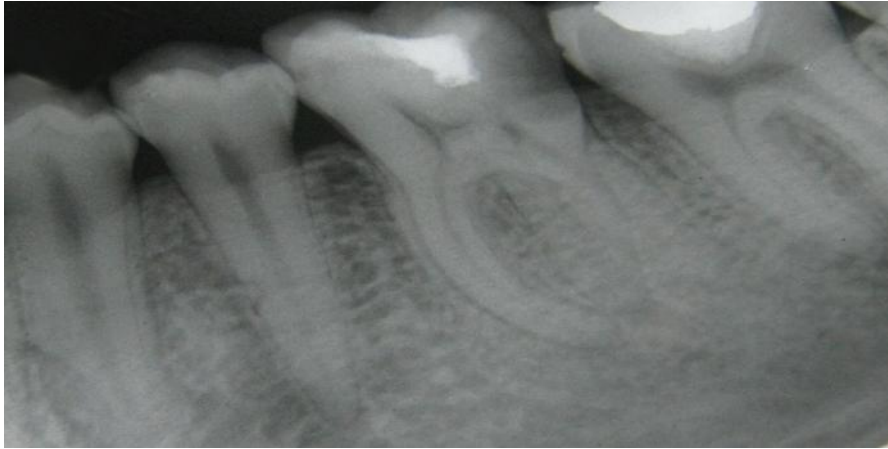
(a) Pre-operative radiograph
